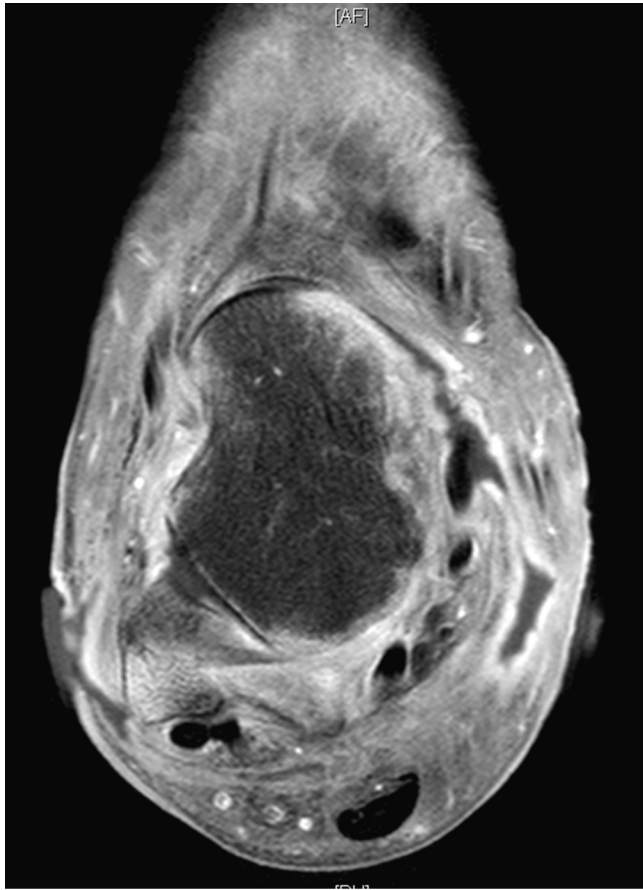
Magnetic resonance imaging (MRI) of the leg showed an osteoarthritis of the midfoot and a talocrural joint effusion associated with a serious loss of skin substance at level of the dorsum foot.
